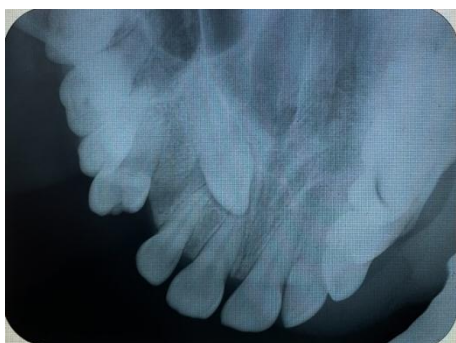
Occlusal radiographic image of tooth 13 impaction.
